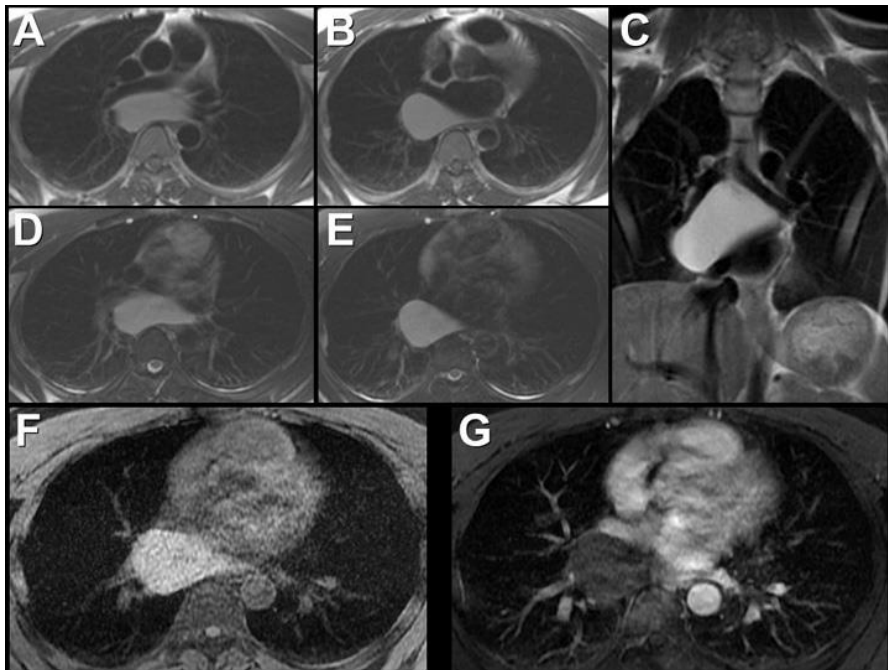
Representative images from thoracic MRI. T1-weighted axial (A and B) and coronal (C) images. Axial T2-weighted imaging with fat saturation (a fluid-sensitive sequence; D and E). Axial unenhanced (F) and enhanced (G) gradient echo imaging.
